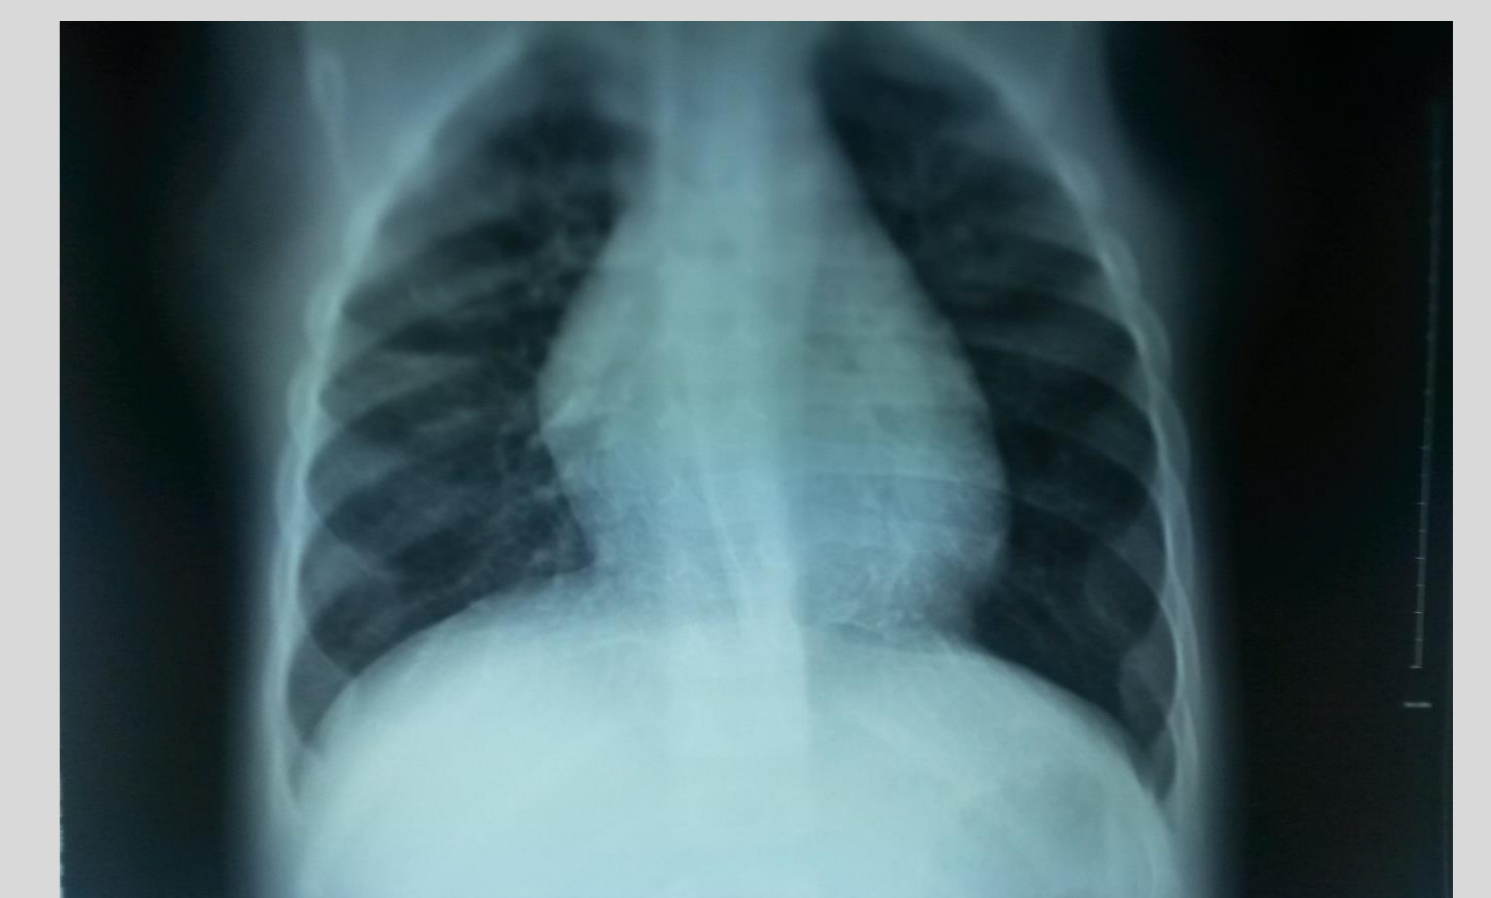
frontal chest x-ray: widening of the chondrocostal junctions without cortical bone demineralization.
